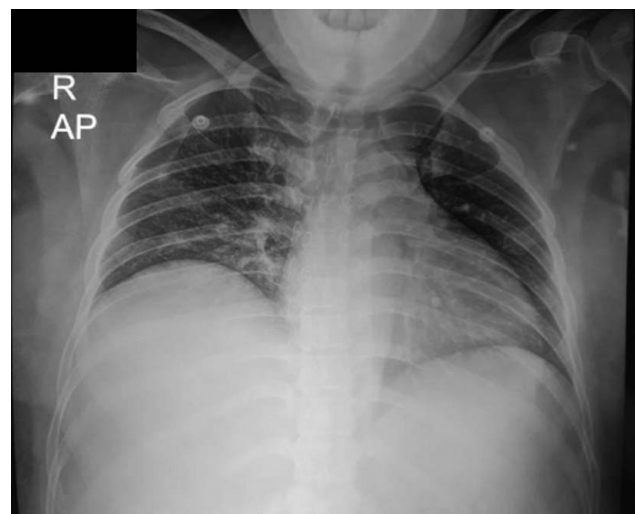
Chest radiograph at admission.
